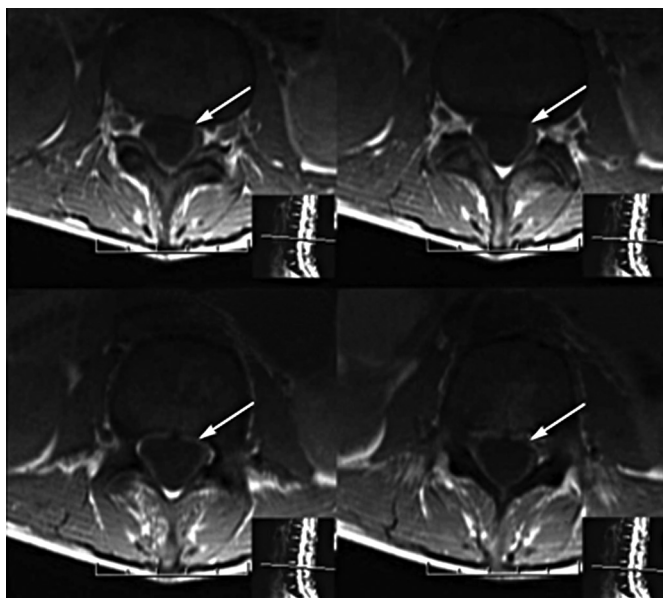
Magnetic resonance imaging of the dorsolumbar spine revealed signs of radiculomyelitis of the cauda equina (arrows).
